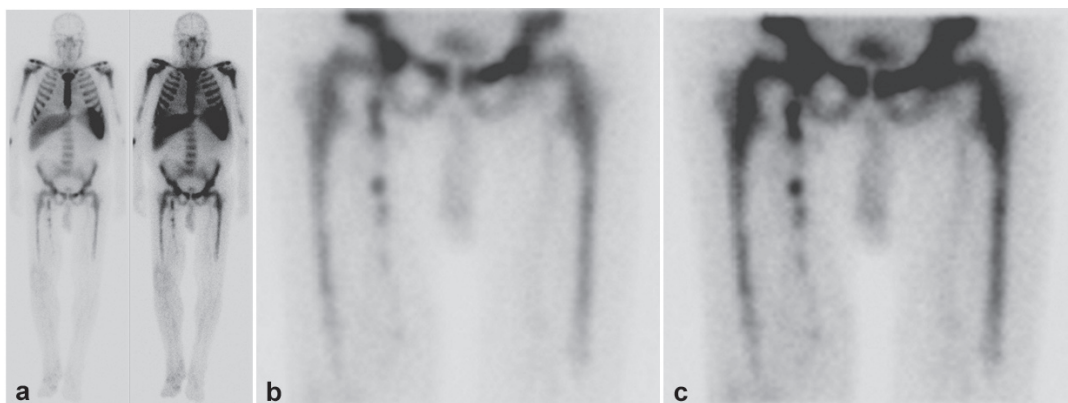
Anti-granulocyte scintigraphy with ^{99m}Tc monoclonal antibodies after: (a) 3.5 h and 24 h: enrichment medial to the right femur and on the lower limb as well as bone marrow expansion (b) 4 h and (c) 24 h: intensive, long and inhomogeneous enrichment medial to the right femur.
